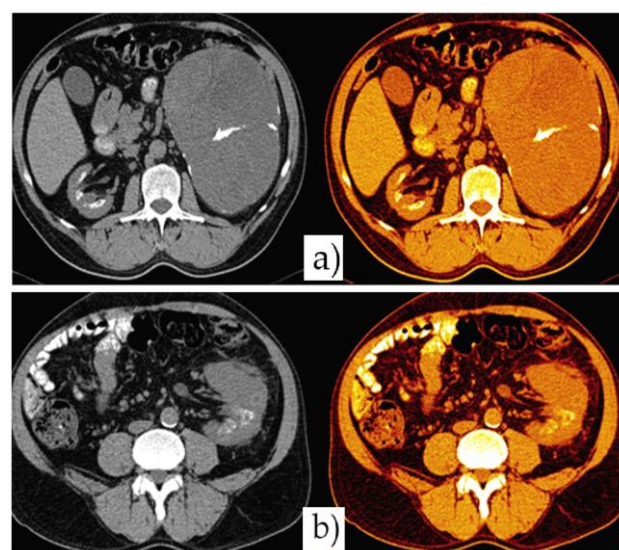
Different color-coded axial sections of native CT scan showing large retroperitoneal mass. The mass seems to originate at the cortical level of the anterior valve of the left kidney, which is located in a lower position than normal.
